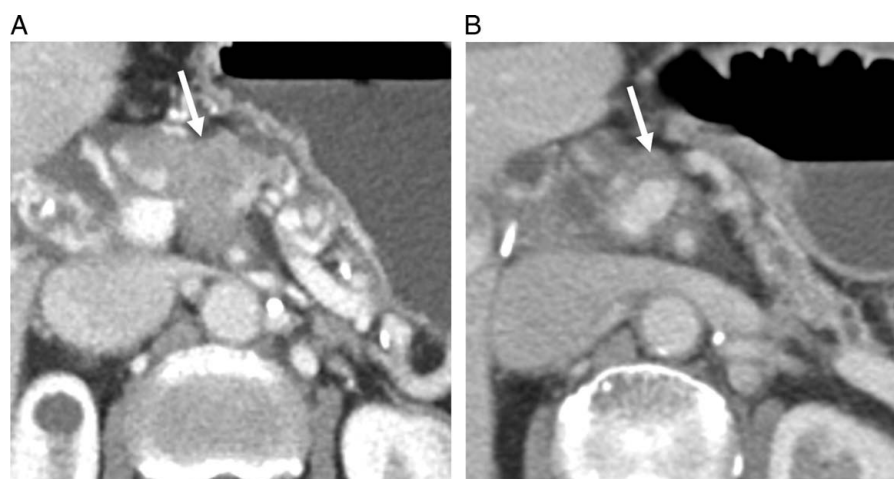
A 76-year-old woman with locally advanced pancreatic ductal adenocarcinoma who underwent neoadjuvant chemotherapy. (A) Baseline axial intravenous (i.v.) contrast-enhanced computed tomography (CT) image in the portal venous phase showed a locally advanced tumor (arrow) with encasement of the celiac artery, common hepatic artery, splenic artery, and portal vein. (B) Restaging CT after neoadjuvant therapy showed decreased tumor size and partial replacement of solid tumor contact with an ill-defined perivascular halo. The patient underwent distal pancreatectomy with poor to no response on pathology examination.
